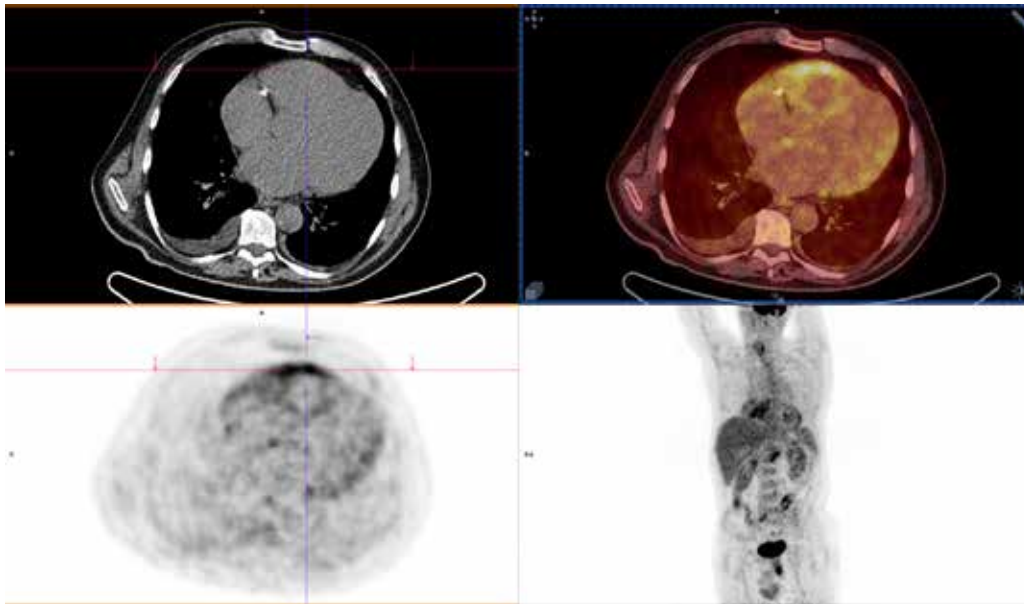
Cardiac sarcoidosis presented as focal FDG myocardial uptake on the FDG PET/CT examination
